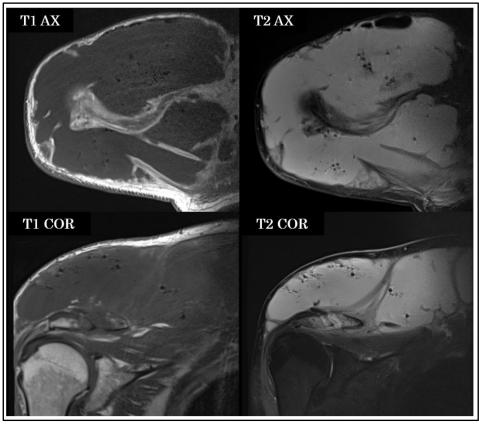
Shoulder MRI confirming soft-tissue abscess (23 March 2025). Axial (T1-weighted and T2-weighted) and coronal (T1-weighted and T2-weighted) sequences show a large heterogeneous soft-tissue collection in the right shoulder containing multiple internal air bubbles, without evidence of underlying osseous involvement, consistent with an emphysematous abscess
